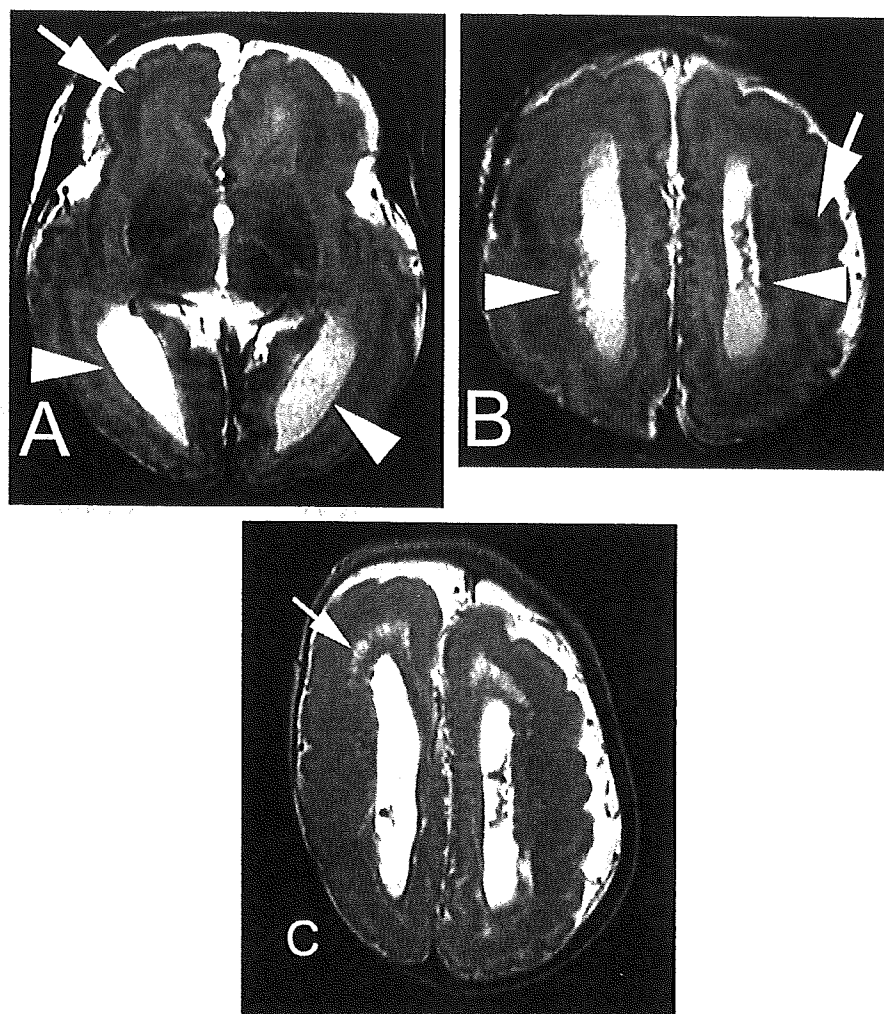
Axial T2-weighted brain MRI scans (repetition time (TR)/echo time (TE), 4000/120 ms; 1.5 T scanner) at 5 days (A and B) and 11 months (C). (A and B) Diffuse pachygyria with SBH (arrows) and periventricular heterotopia (arrow heads) can be observed. (C) Marked changes are observed in the white matter; the affected regions are isointense to the regions containing the cerebrospinal fluid (arrow). The feather-like configurations are suggestive of an enlarged perivascular space.
